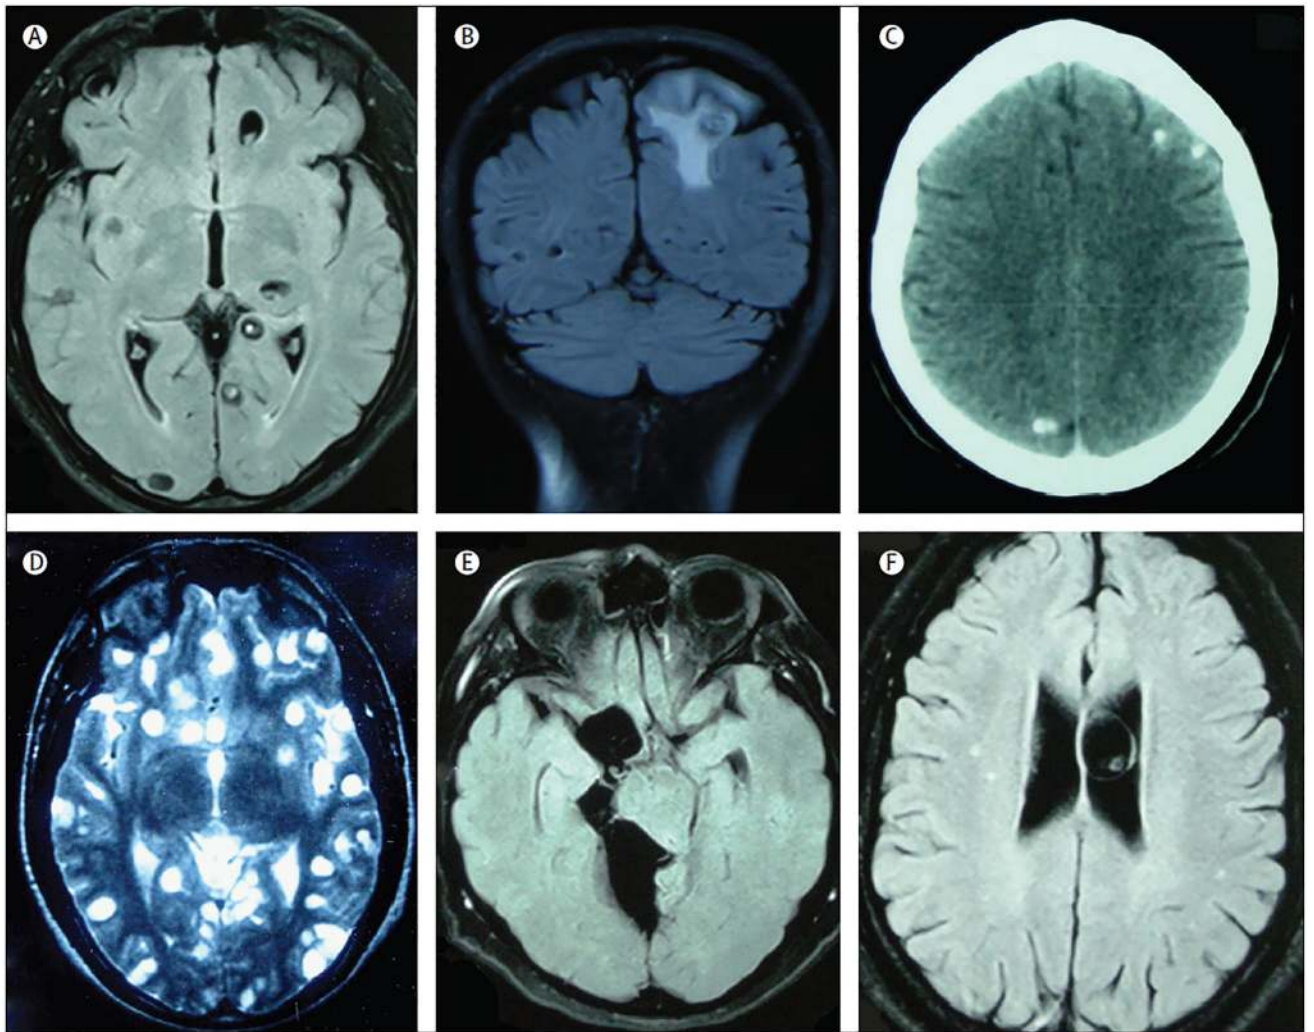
MRI imaging of human neurocysticercosis
